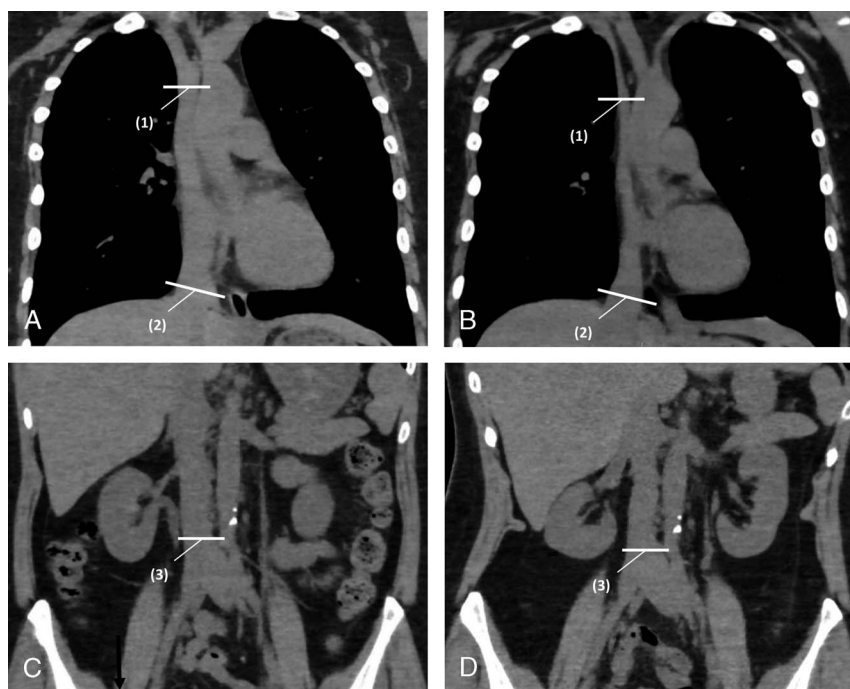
Measured points on the vena cava. Each coronal reformatted unenhanced CT image demonstrates the 3 points where the area size and flattening ([major axis – minor axis]/major axis) measurements of the vena cava were performed. These points include (1) directly below the junction of the bilateral cephalic veins, (2) at the height of the diaphragm, and (3) directly above the junction of bilateral common iliac veins. A, Supine position (thoracic). B, Upright position (thoracic). C, Supine position (abdominal). D, Upright position (abdominal).
